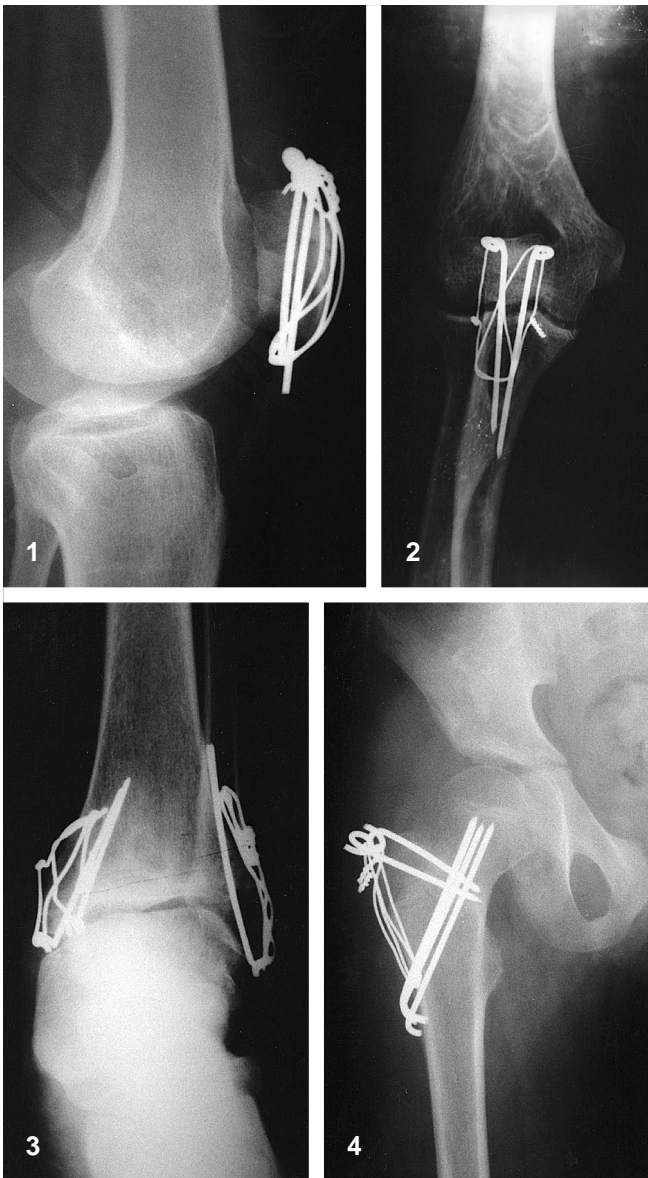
Postoperative 9th week lateral radiograph of a transverse patellar fracture. Complete fracture healing was seen
